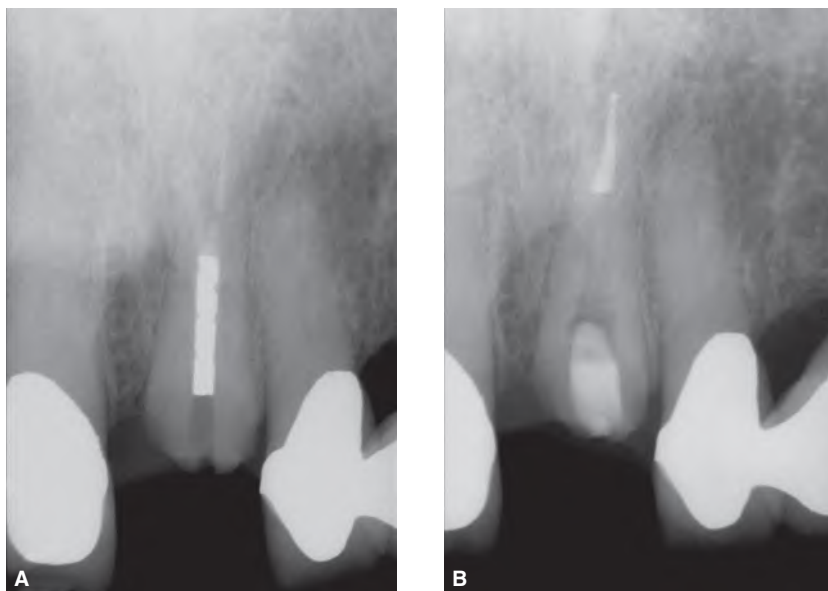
A. Preoperative radiograph of a maxillary central incisor showing a post fractured subcrestally; this example serves to emphasize the importance of treatment planning. B. Post-treatment radiograph following post removal, retreatment, and post space done prior to crown lengthening and restorative treatment.
